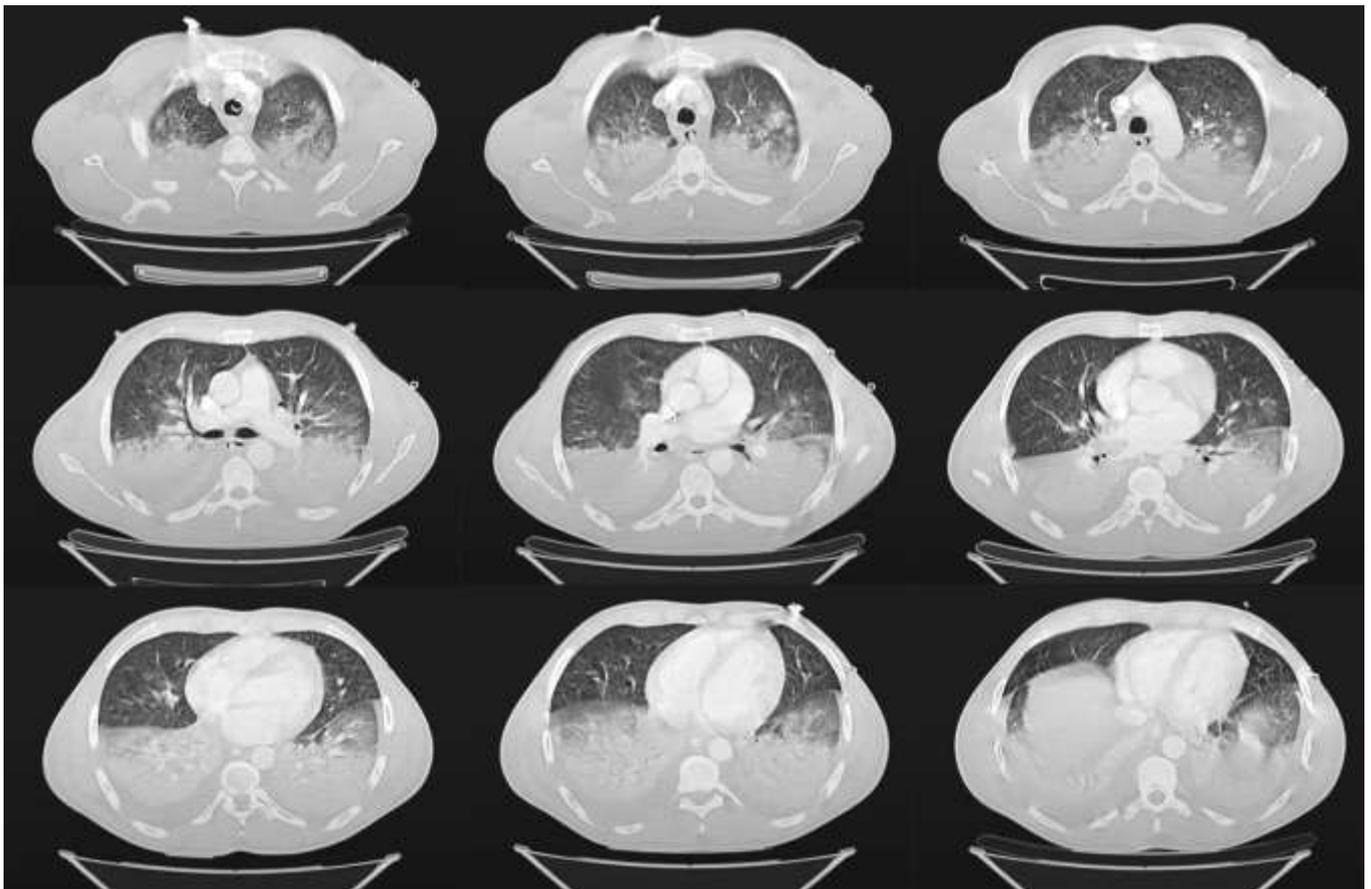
Axial Computed Tomographic Slices in the Pulmonary Window Show Ground Glass Opacities with a Tendency toward Bronchial Alveolar Consolidation, a Predominance in the Bases, and the Presence of Fluid Compatible with Bilateral Pleural Effusion.
